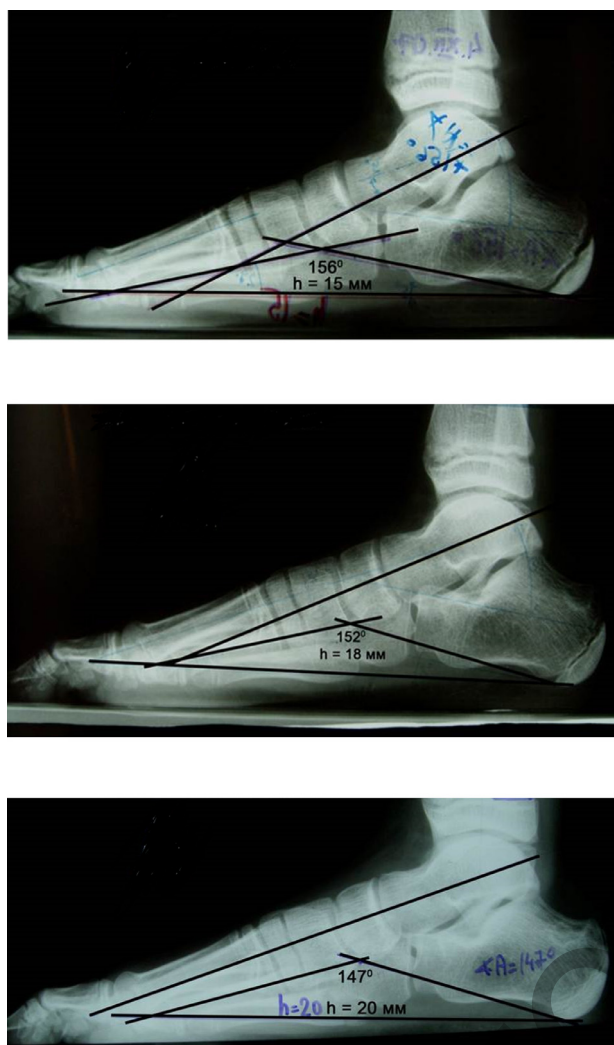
Radiographic images: (A) preoperatively, (B) at 6 months postoperatively, and (C) at 12 months postoperatively.
